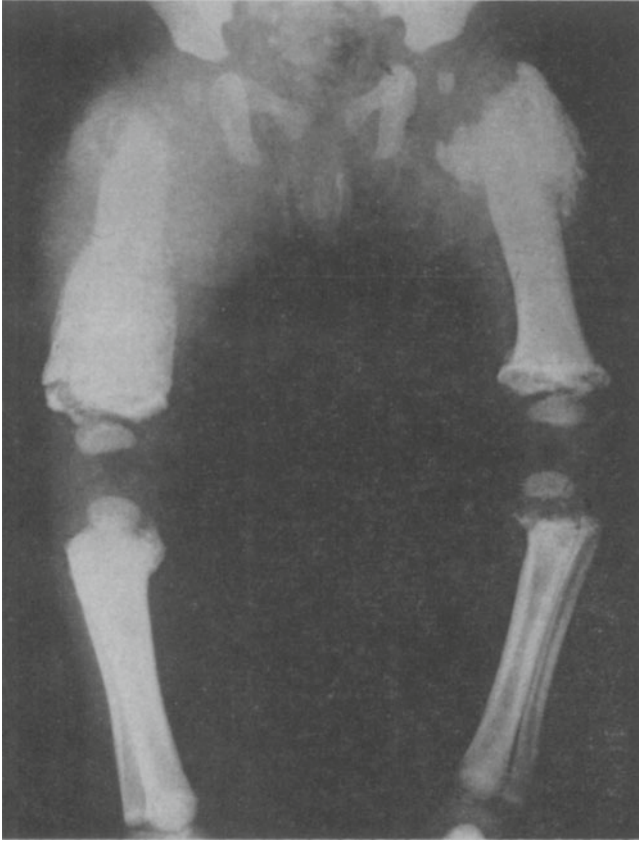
Female, 7 1/2 months with a history of recurring abuse, including being shaken while held by legs 4-6 weeks prior to film. Note recent (2-3 weeks) metaphyseal fragmentation, older (4-6 weeks) periosteal reaction, and remote (2-4 months) external cortical thickening. Note also normal osseous structure of uninjured pelvic bones. (By permission of *Amer J Roentgenol.*)
